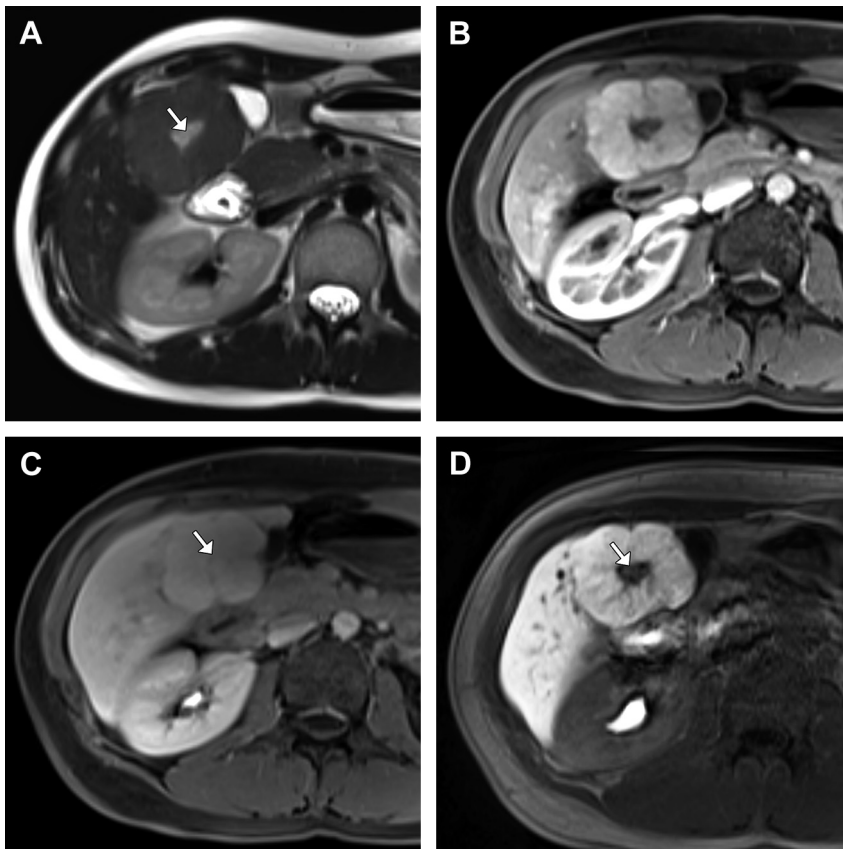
FNH with central scar; gadoxetate disodium-enhanced MR imaging. (A) Slightly T2 hyperintense mass has a focal T2 bright central scar (arrow). (B) The mass demonstrates uniform arterial hyperenhancement. (C) There is delayed enhancement of the central scar during equilibrium phase (arrow). (D) On 20-minute delayed hepatocyte phase images, the mass retains contrast while its central scar does not (arrow).
